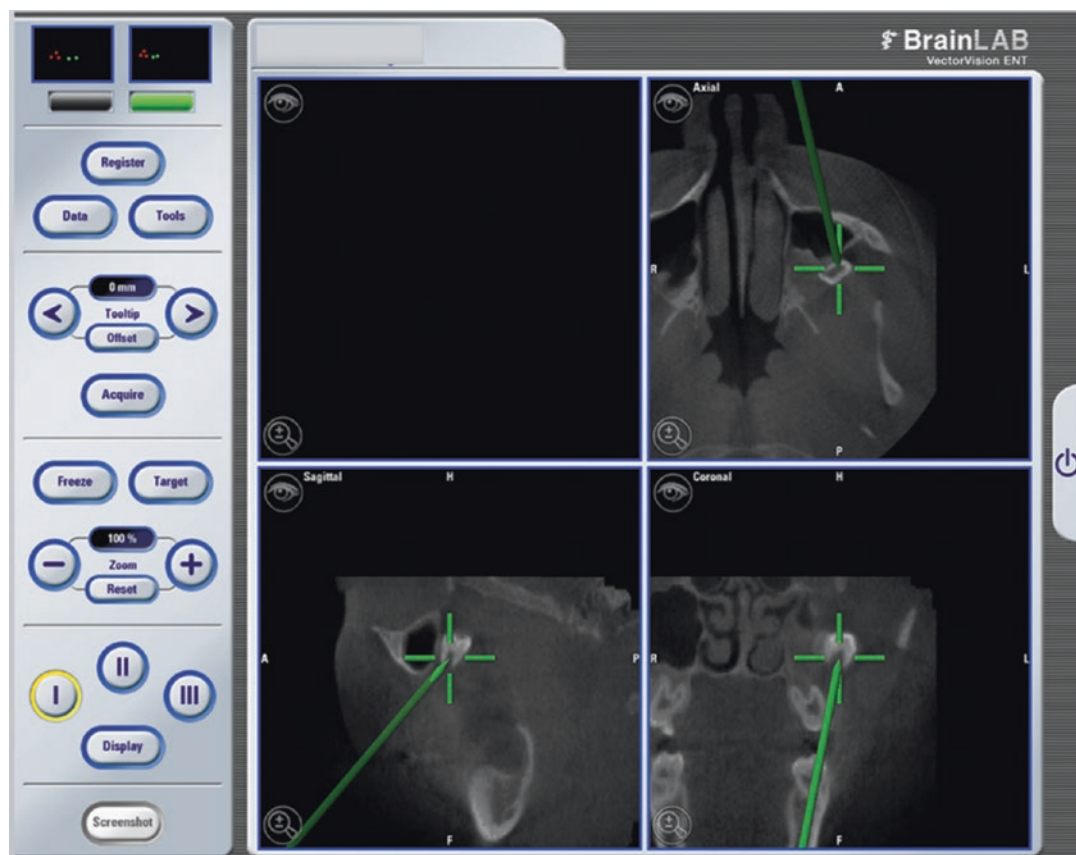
Surgical planning on the CBCT image data set: Identification of the position of a dislocated third molar in the image data
